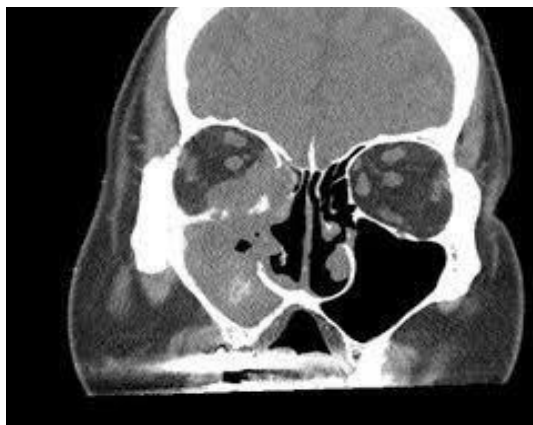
soft tissue CT image show acute invasive fungal sinusitis in rt maxillary sinus (<https://radiopaedia.org>)
